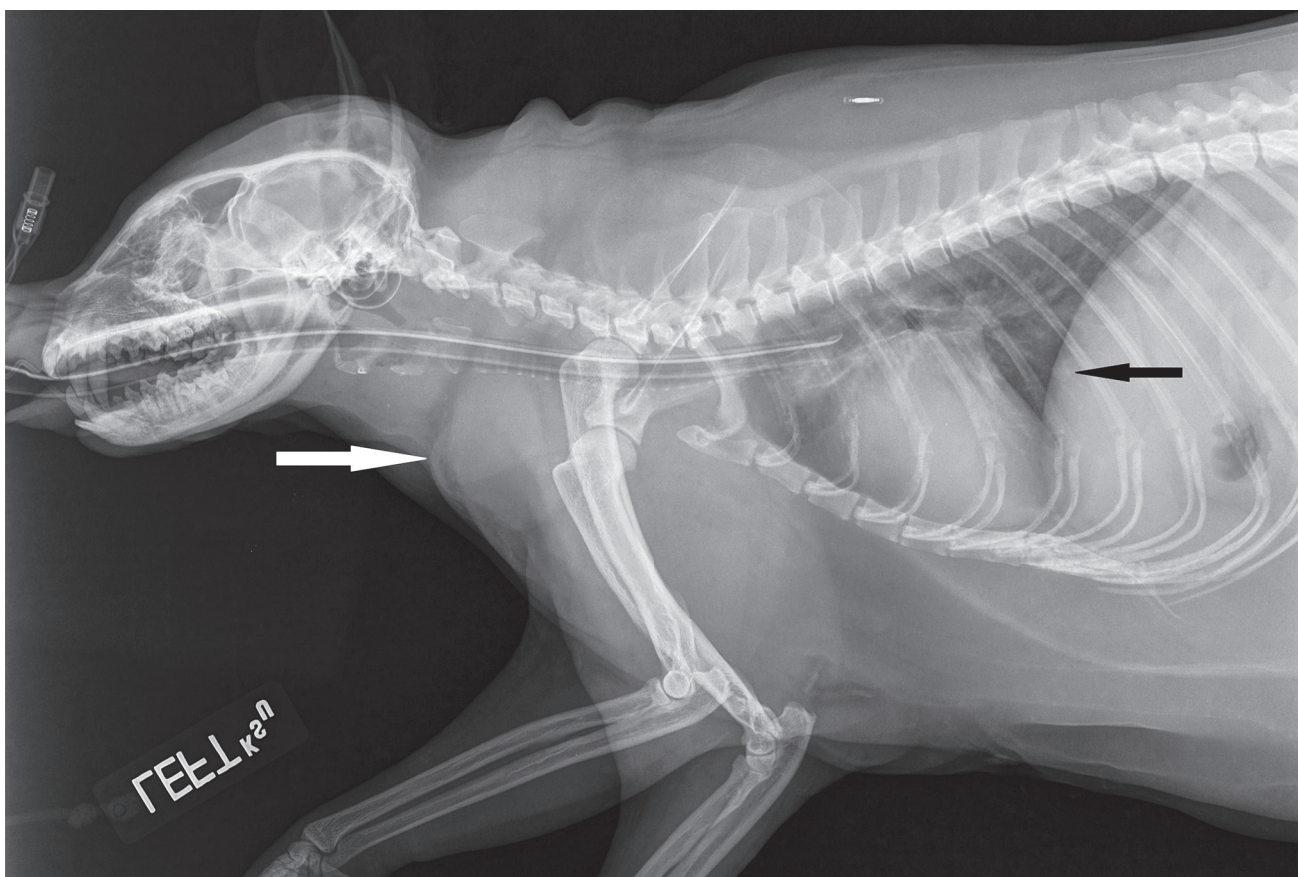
Left lateral cervical and thoracic radiograph of the raccoon. Notice the ventral cervical soft tissue opacity (white arrow) and pulmonary nodule (black arrow).
